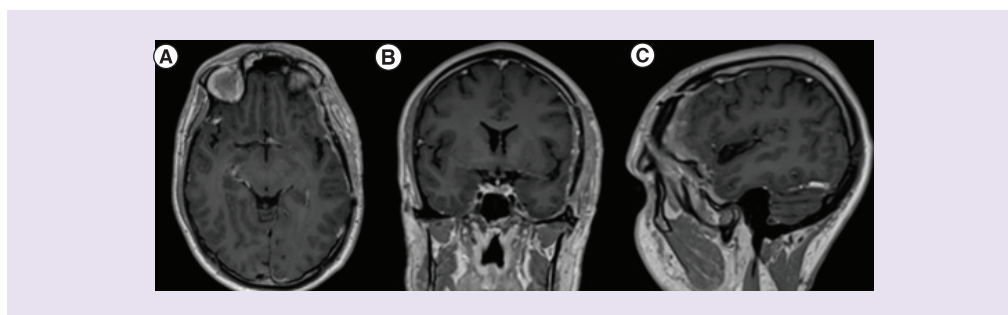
Post-operative imaging. 3 months postoperative axial (A), coronal (B) and sagittal (C) T1-weighted MRI with gadolinium showing total resection of the meningioma and no signs of recurrence. MRI: Magnetic resonance imaging; T1: Superior temporal gyrus.
